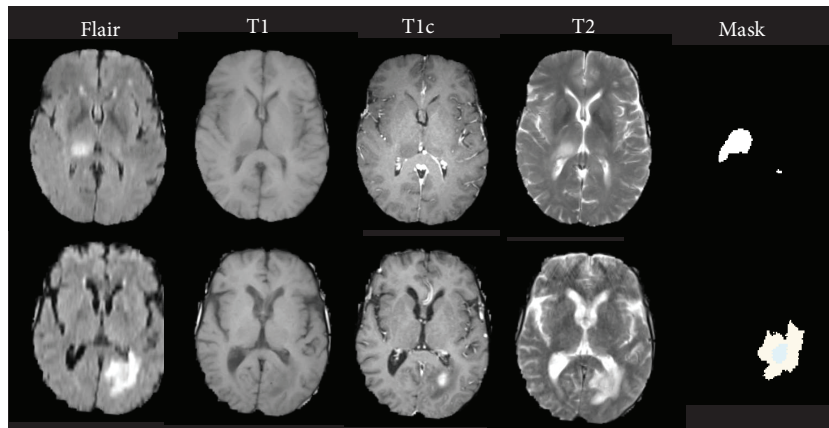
Examples of the four MRI modalities and the corresponding tumor masks from two randomly selected GBM patients.
